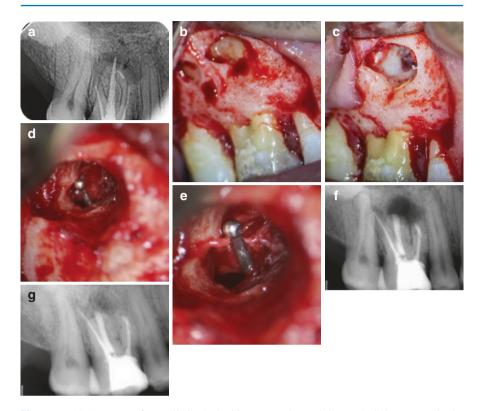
(a) Fragment of a small-sized Ni-Ti instrument beyond the nearly 90° curvature in the mesiobuccal canal of the first maxillary molar. (b) Immediate post-obturation radiograph short of the working length with transportation in the mesiobuccal canal. The instrument was not removed or bypassed. (c) Reflection of a full mucoperiosteal flap. Buccal bone dehiscence and root curvature can clearly be seen. (d) Apicoectomy. (e, f) Fracture of a micro-burnisher during retrograde cavity preparation. (g) Immediate postoperative radiograph. Note the MTA retofillings in the palatal and mesiobuccal roots. (h) The 12-month recall examination revealed healing process of the periapical tissues (Courtesy Dr. Ch. Beltes)
